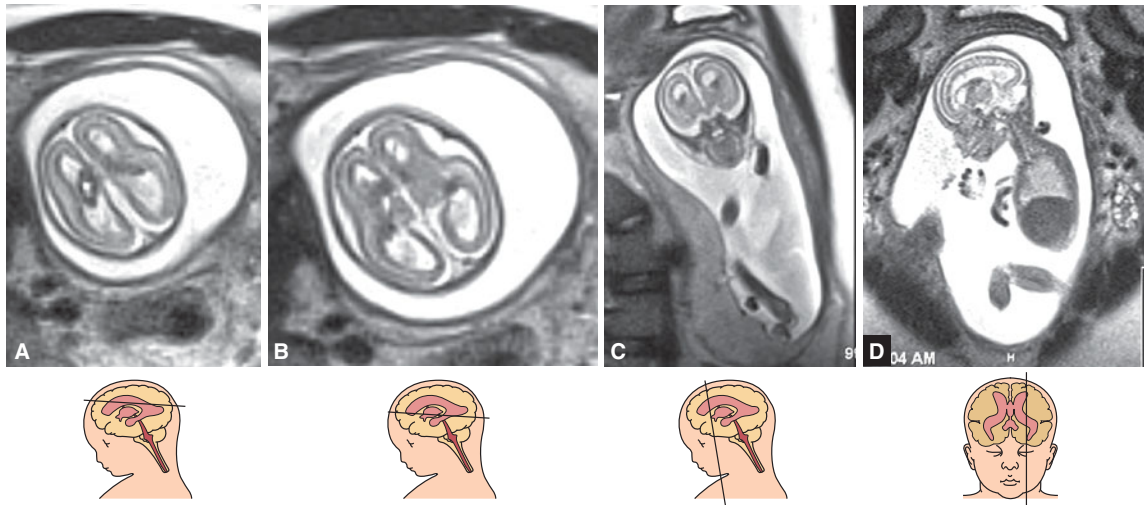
T2-weighted fetal MRI at 19 postmenstrual weeks depicting grade II intraventricular hemorrhage. (A, B) Axial sections. (C) Coronal section. (D) Sagittal section.
